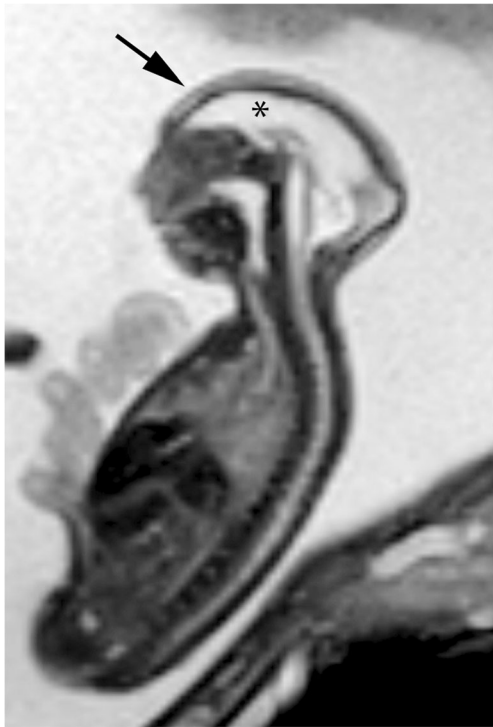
Zika virus in a 22-week gestational age fetus. Sagittal balanced turbo field echo MR image demonstrates profound microcephaly (arrow) with severe cerebral volume loss (asterisk)
